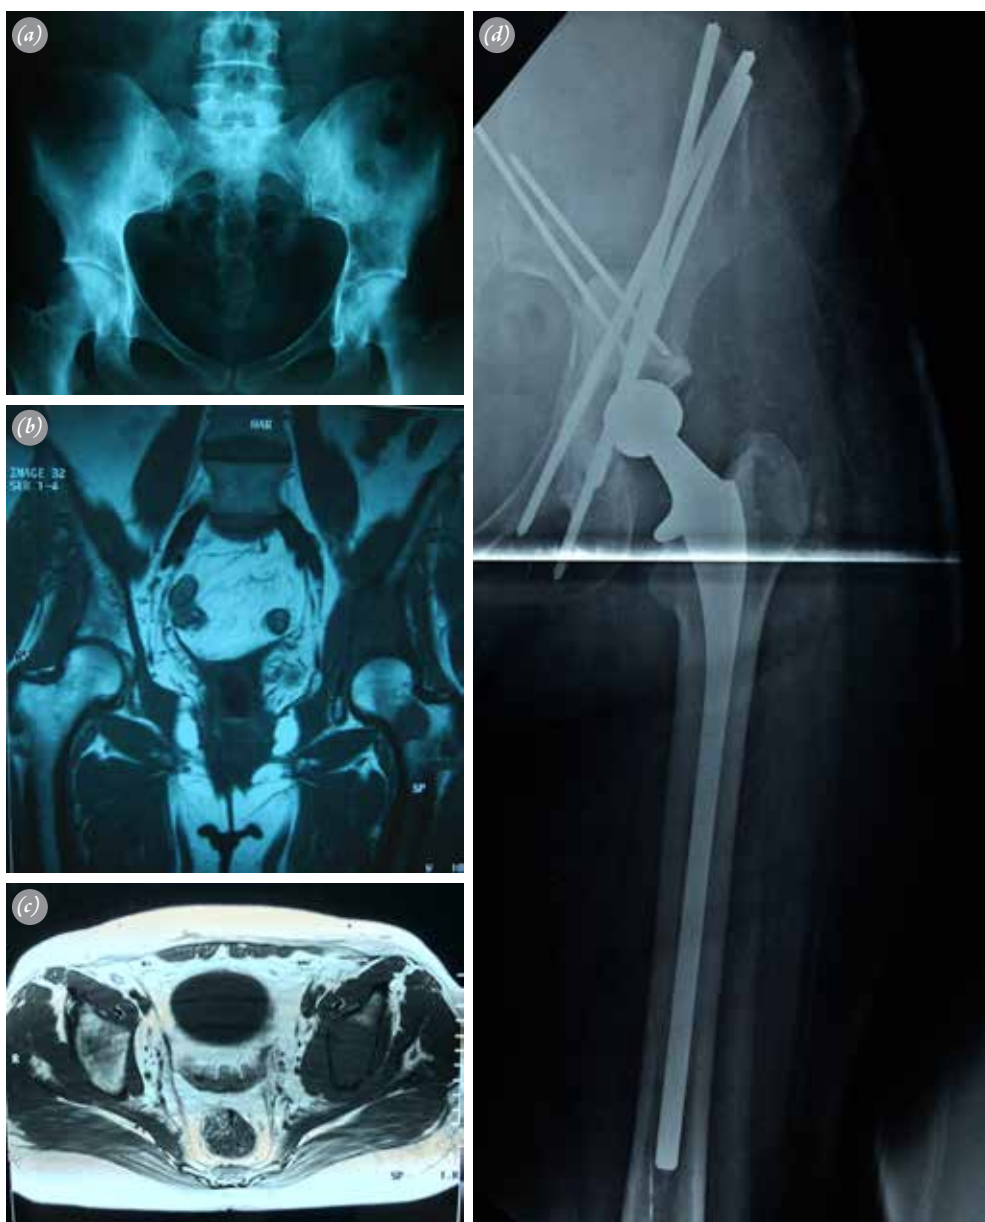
48-year-old female with metastatic breast carcinoma. Radiograph and magnetic resonance imaging of the pelvis showed extensive involvement of the periacetabular region. A metastatic lesion in the femoral neck was also seen (a–c). This Harrington class III lesion was managed by total hip replacement and acetabular reconstruction with threaded pins and cemented acetabular cup (d). Postoperative radiation therapy was also applied. [Color figures can be viewed in the online issue, which is available at www.aott.org.tr]
